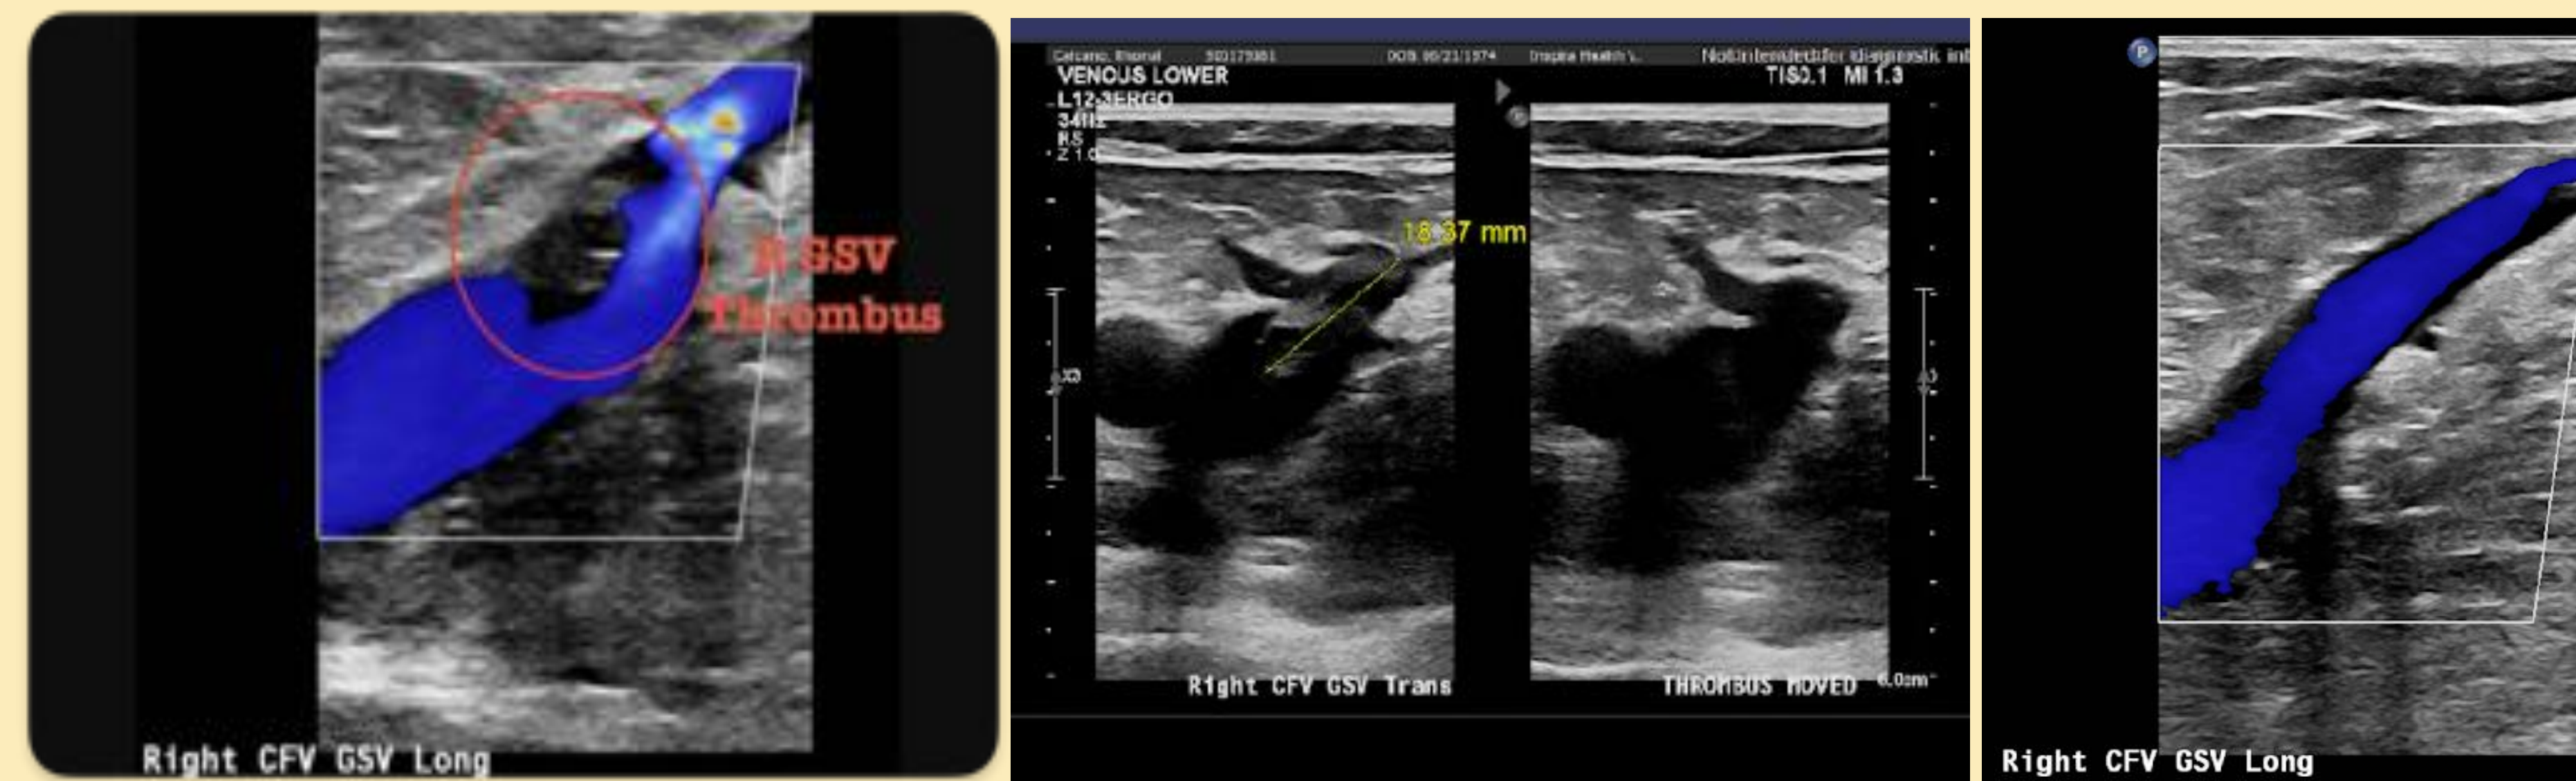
US venous duplex showing the presence of thrombus in R proximal GSV with color doppler (Left) and measurement (Right).
